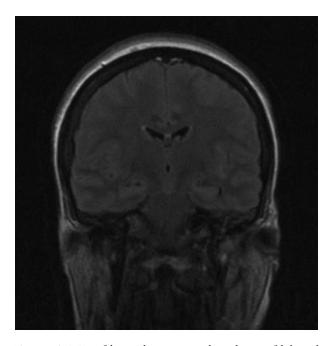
MRI of brain showing partial resolution of bilateral hippocampal hyperintensity after steroid therapy.
